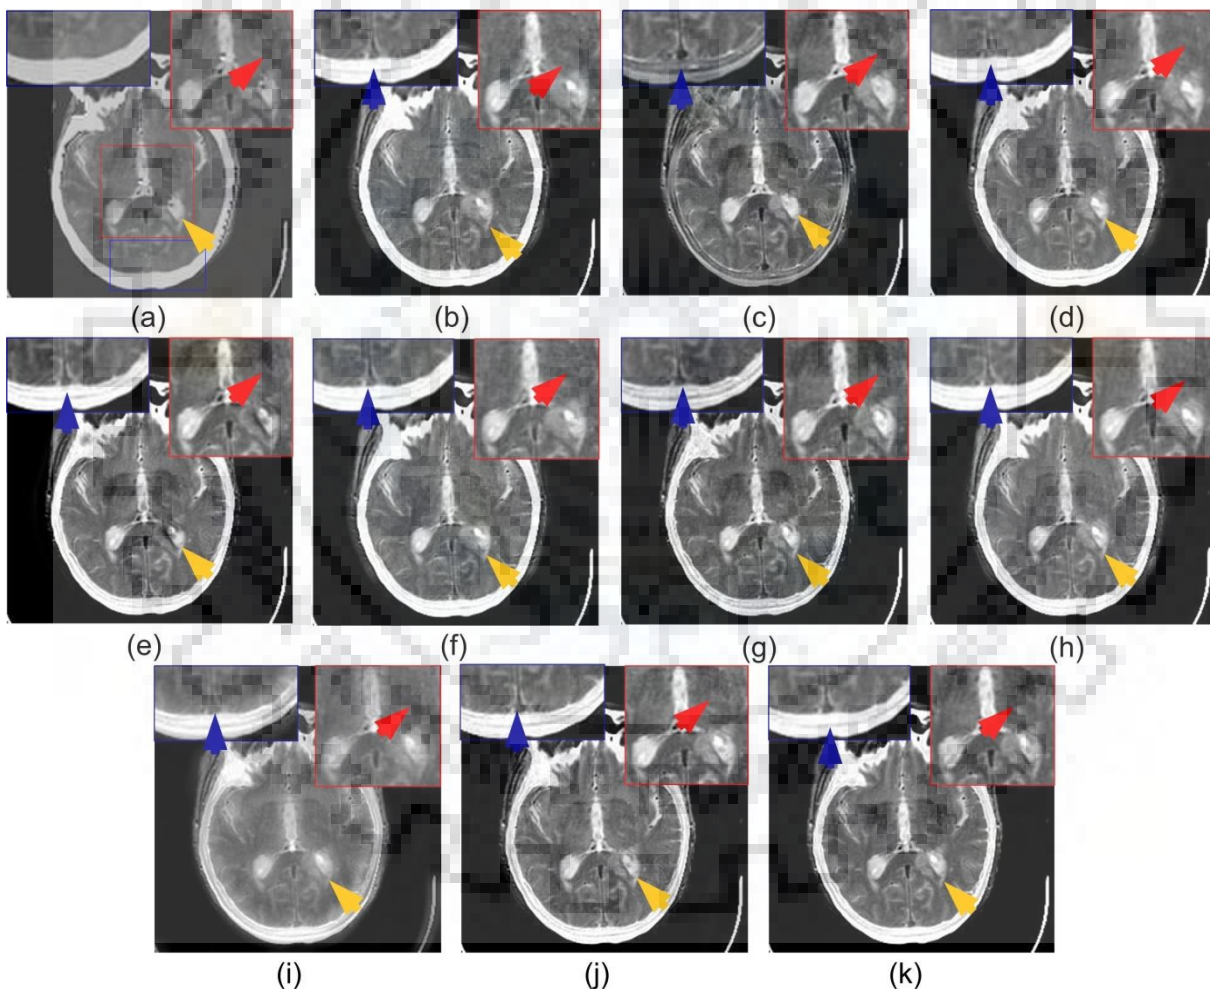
CT-MR image pair-3 shown in Figure 6.5. Comparison of fused images obtained by (a) Nirmla et al., 2016 [137] (b) Das and Kundu, 2012 [34] (c) Li et al. (GFF), 2013 [94] (d) Ganasala and Kumar, 2016 [48] (e) Yang et al., 2017 [203] (f) Zhu et al. (HMSD-GDGF), 2018 [218] (g) Liu et al., 2017 [111] (h) C-MIF method (i) Hermessi et al., 2018 [57] (j) Hou et al., 2019 [59] (k) Proposed CNN-MIF
